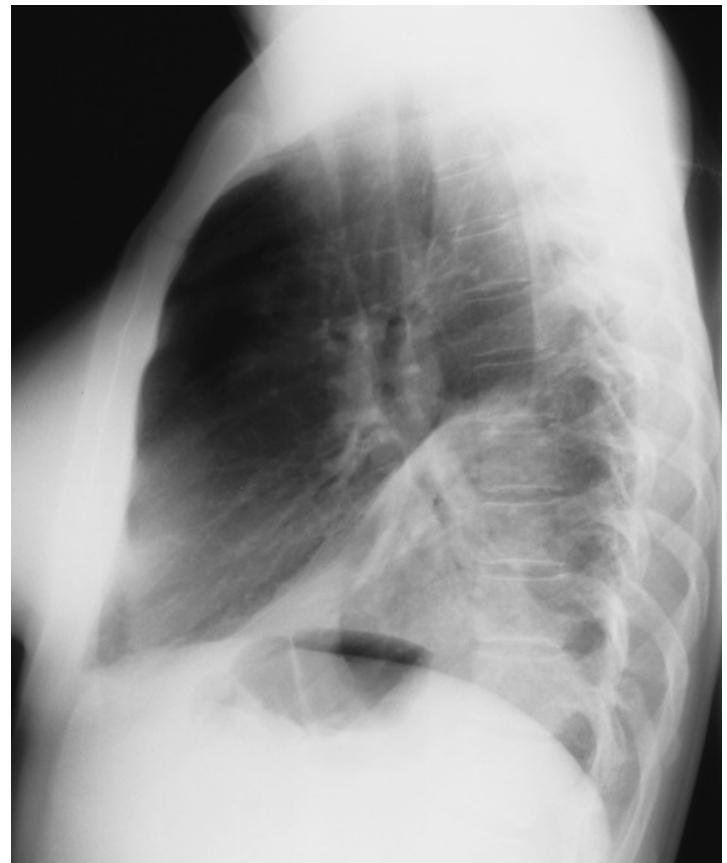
Infiltrate is present in the lower lobe with a significant increase in volume. The lateral radiograph confirms the tentative diagnosis of lower lobe involvement. Marked protrusion of the oblique fissure indicative of increased volume. The findings respect the anatomic boundaries.
